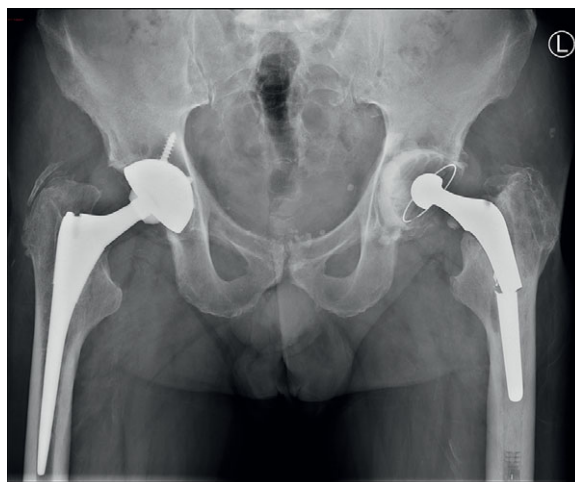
Anteroposterior (AP) radiographs pelvis
